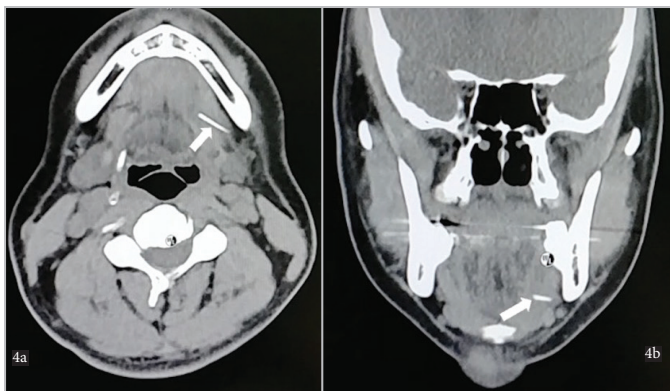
(a) Axial and (b) coronal computed tomography scan of the neck (second CT scan) showing a dense tubular structure in the left hyoglossus muscle (white arrow)
